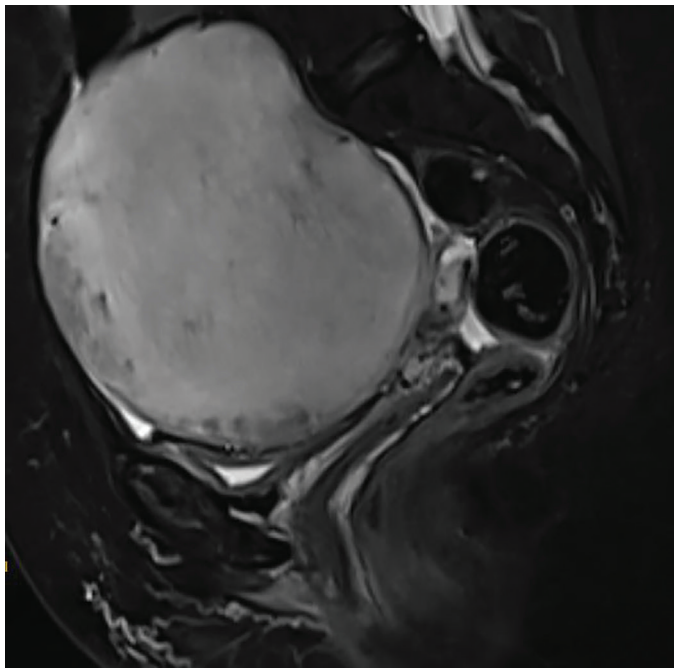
Preoperative MRI showing the large adnexal mass
